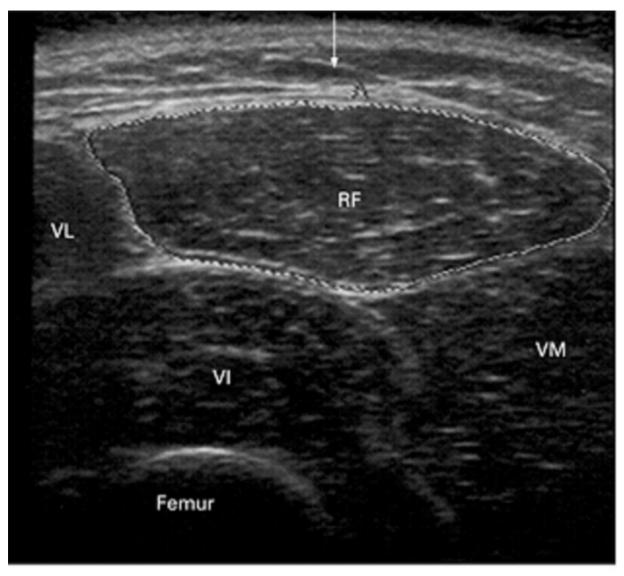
Ultrasound of the quadriceps
